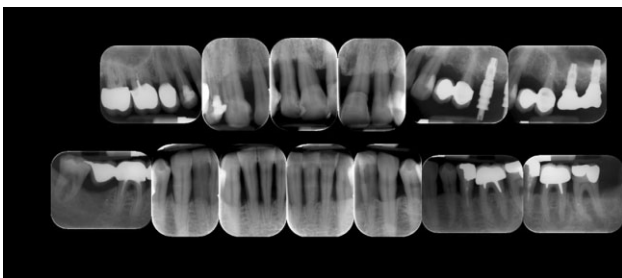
Preoperative X-rays. Significant generalized bone loss with less than 20% residual bone in the upper and lower anterior teeth.
